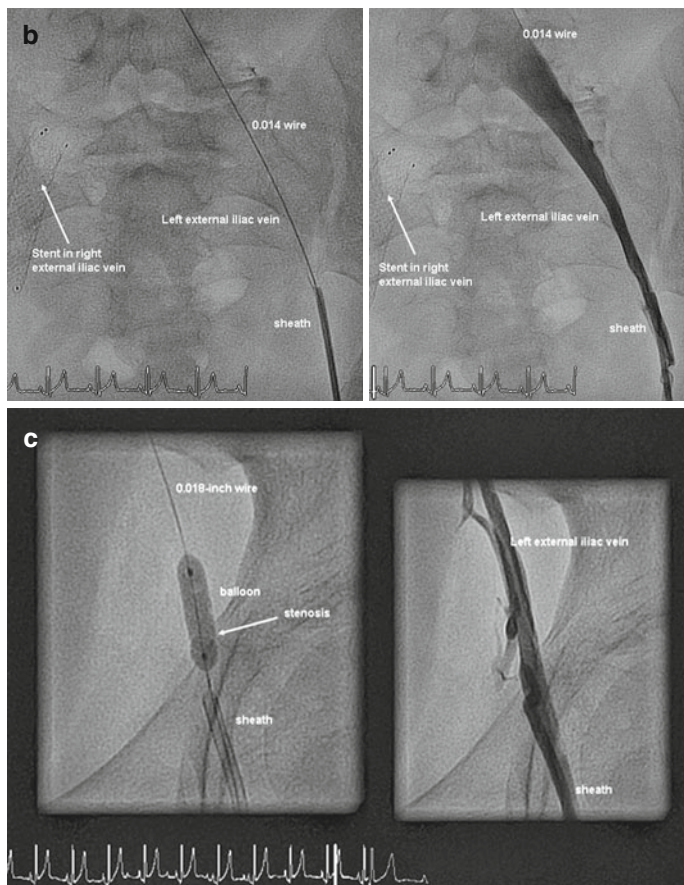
(a) Iliac and femoral vessel area around the inguinal ligament. Venous puncture and sheath implantation can be performed via the right iliac vein under sonographic control. (b) Example of an angiographic and fluoroscopic picture in a 12-year-old girl with multiple vascular punctures and sheath/central line implantation and status post-stenting of the right iliac vein due to stenosis. (c) Balloon dilatation of iliac and femoral stenosis within sheath removal from the iliac vein. Complete treatment of the vessel stenosis after sheath removal was documented, saving this vessel as an access route for further catheterizations
